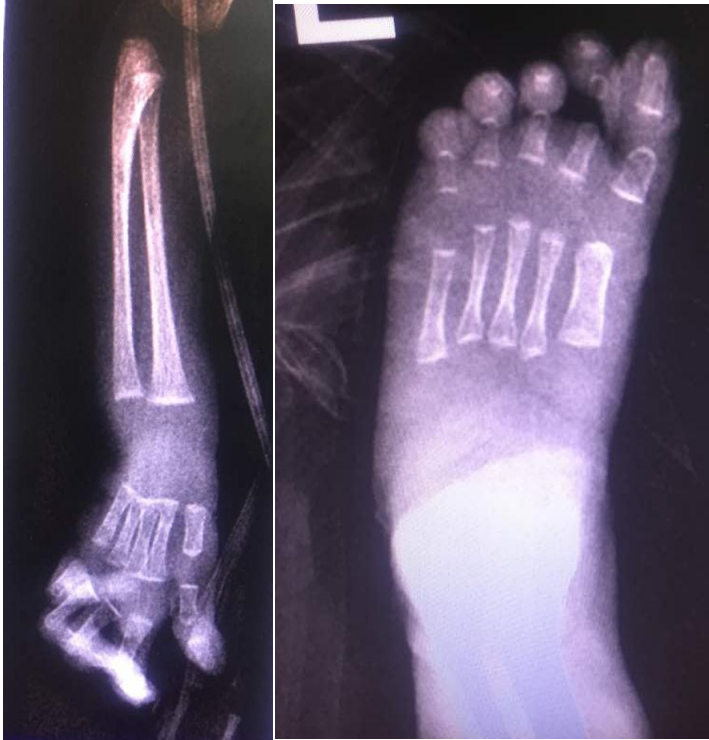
Radiography of foot and hand. Left (deformed hand). Right (club foot).
